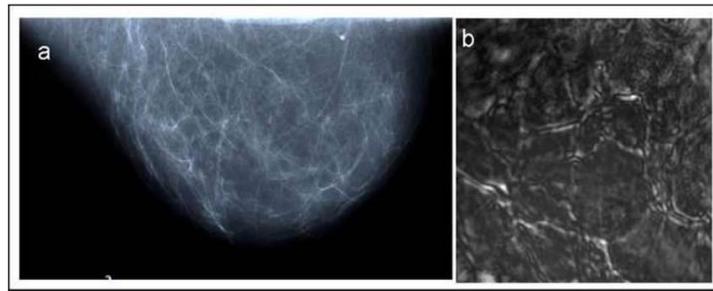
Breast Images of a healthy breast. (a) X-ray mammography of the entire breast and (b) its corresponding vibro-acoustographic image focused at 2 cm depth from the skin ($\Delta f = 50$ kHz) [38].
